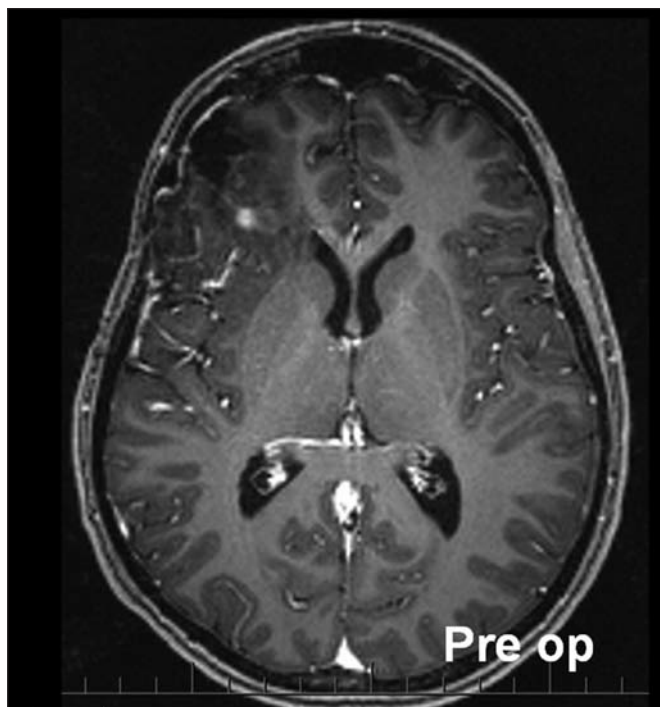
Axial T1-weighted Post Gadolinium (by 3 Tesla Siemens Trio) showing the presence of an anaplastic oligodendroglioma involving the right frontal lobe and the anterior aspect of the cortex of the insula. No evidence of leptomeningeal or ventricular involvement.
